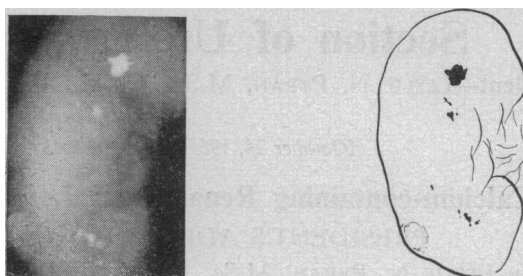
Radiograph of the excised kidney of the patient referred to in Fig. 1, showing in addition to the large stone in the upper calyx, multiple smaller calculi and calcific foci which had not been detected in the pre-operative radiograph.
